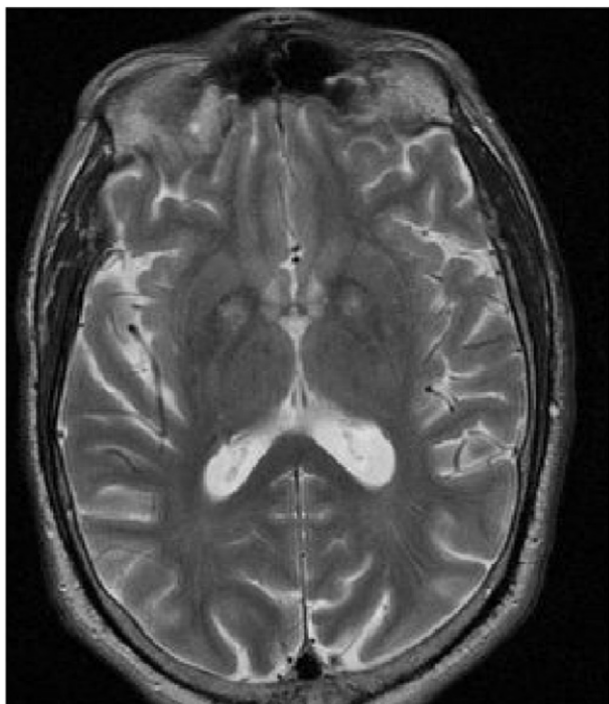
T2 weighted MRI of the basal ganglia reveals hyperintensity in the globus pallidus, a pattern previously described with carbon monoxide intoxication, neurological degeneration with brain iron accumulation and perinatal hypoxic injury, but not with Agent Orange exposure.
